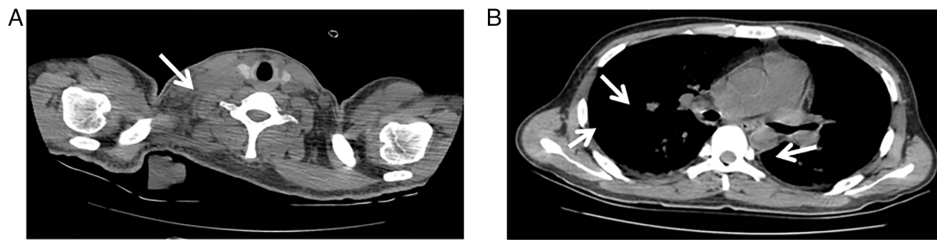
(A) Neck CT scan shows multiple enlarged lymph nodes on the right side of the neck, some of which appear fused; (B) Chest CT scan shows multiple nodules in both lungs with irregular and lobulated edges, accompanied with multiple enlarged lymph nodes in the mediastinum and bilateral hilum. CT, computed tomography.
